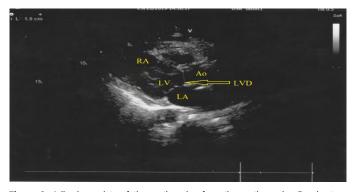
Adhesion points of the aortic valve from the aortic anulus line by twodimensional imaging of the parasternal long axis with the ECHO probe. (RA: Right Atrium; LV: Left Ventricle; LA: Left Atrium; Ao: Aorta; LVD: LVOT: Left Ventricular Out Flow Tract).
